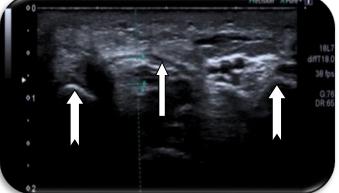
Sonographic cross sectional view of the carpal tunnel of both hands in healthy volunteer displaying cross sectional area (CSA) of the median nerve (A,B), Palmar bowing (PB) of the flexor retinaculum (C,D) and flattening ratio (FR) of the median nerve (E,F).
